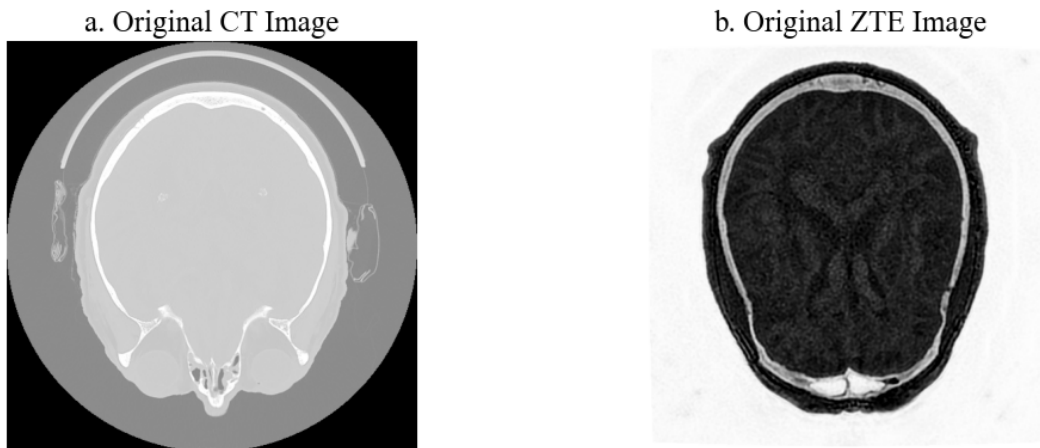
Raw images before processing. (a) Conventional CT and (b) normal ZTE images of one patient before any preprocessing or registration.
